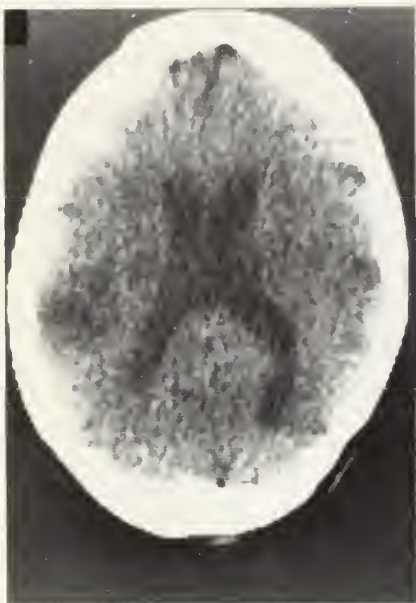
Unenhanced CT of Case 1 demonstrating mildly enlarged lateral ventricles; there is no evidence of blood in the occipital horns.
